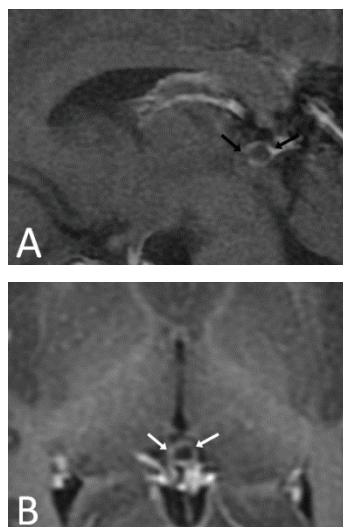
On MR imaging, a pineal cystic transformation which appears hypointense (A) in post-contrast T1-weighted sagittal sequences and (B) in post-contrast T1-weighted axial sequences.
